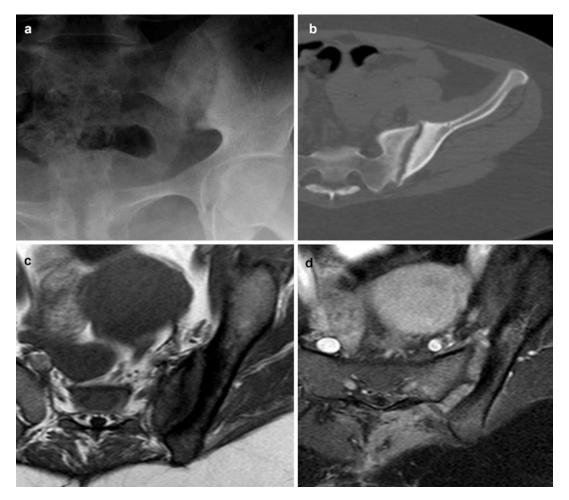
(a) Plain radiograph of the left sacroiliac joint demonstrates sclerotic changes on the iliac side of the sacroiliac joint and widening of the sacroiliac joint on the left side. (b) demonstrates sclerotic changes of the left sacroiliac joint on the iliac side with widening of the sacroiliac joint. (c) Axial T1-weighted image demonstrates sclerotic
